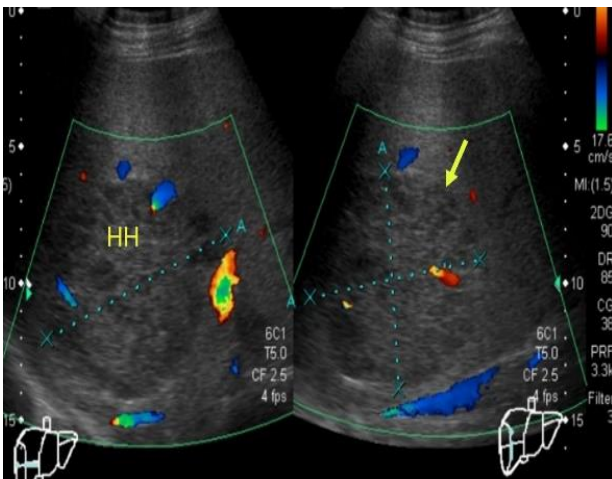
Liver ultrasound, with the presence of a rounded lesion in segment VIII of Couinaud (arrow), poorly defined borders, with heterogeneous echogenicity measuring $96 \times 80 \times 85$ mm, with an approximate volume of 342 cc, compatible with hepatic hematoma (HH).
